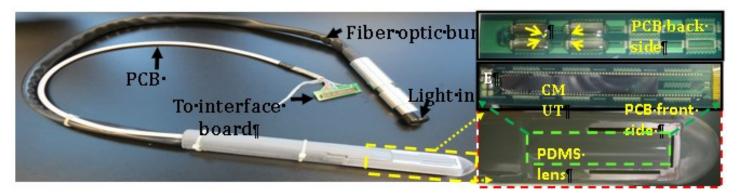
Figure Appendix 2. Image showing the hand held photoacoustic probe. IC and CMUT are flip-chip bonded and placed on PCB (printer circuit board). PCB is rested in between two parallel fiber optic light guides that focus light 0.5 inch above the CMUT surface. The entire PCB-light guide assembly is housed in acrylic probe that has similar dimensions as conventional ultrasound probe.
